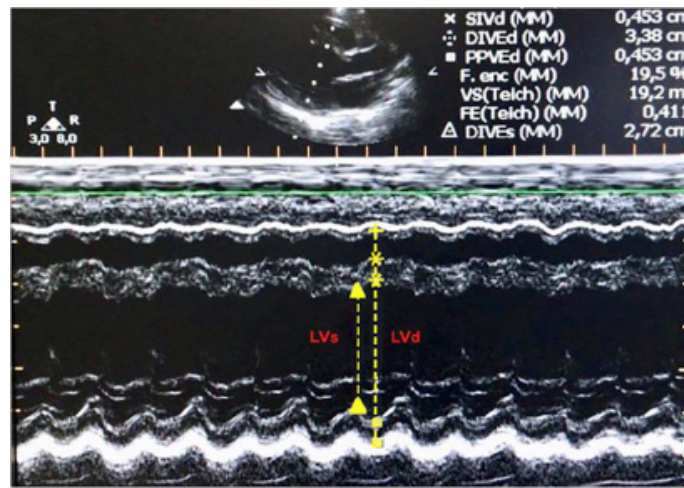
Transthoracic echocardiogram, short axis parasternal view (papillary muscle level), showing reduced EF and LV SF of the LV in a case of myocarditis with moderate myocardial dysfunction (EF = 44%; SF = 19.5%). LV: left ventricle; EF: ejection fraction; SF: shortening fraction.
